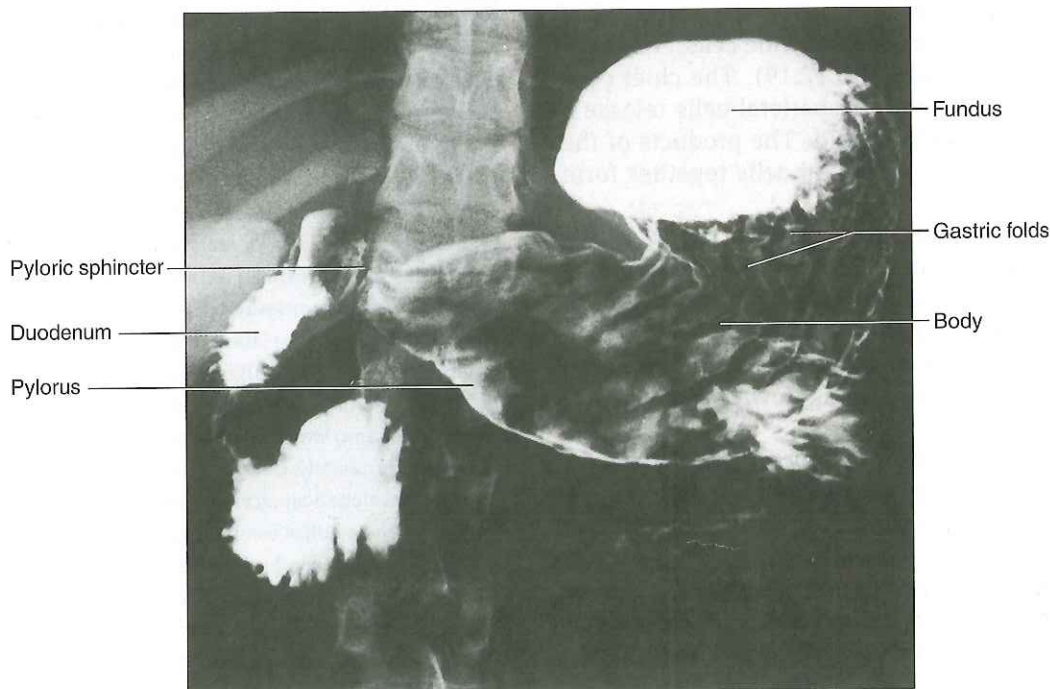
Radiograph of a stomach. (Note: A radiopaque compound the patient swallowed appears white in the radiograph.)
